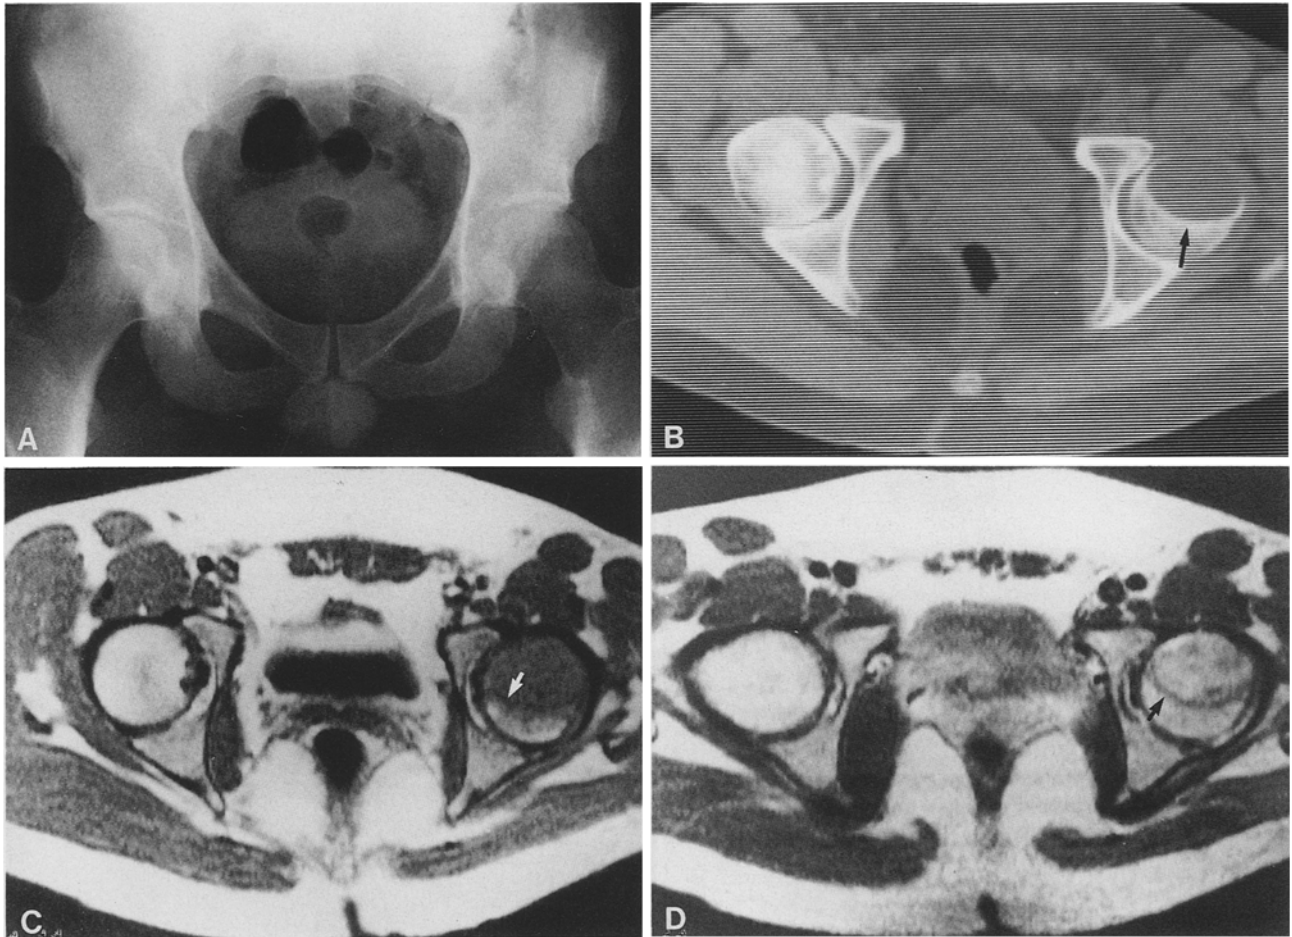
A Plain film shows a pathological fracture (*arrowhead*) in this femoral neck lesion. B CT showing marked cortical thinning and reactive sclerosis at margin (*arrow*). C Axial T1 MRI (TE28, TR500) showing low signal tumor and lower signal margin (*arrow*). D T2-weighted image (TE56, TR2000) better demonstrates the low signal margin than T1-weighted image (*arrow*), which corresponds to reactive sclerosis on CT
